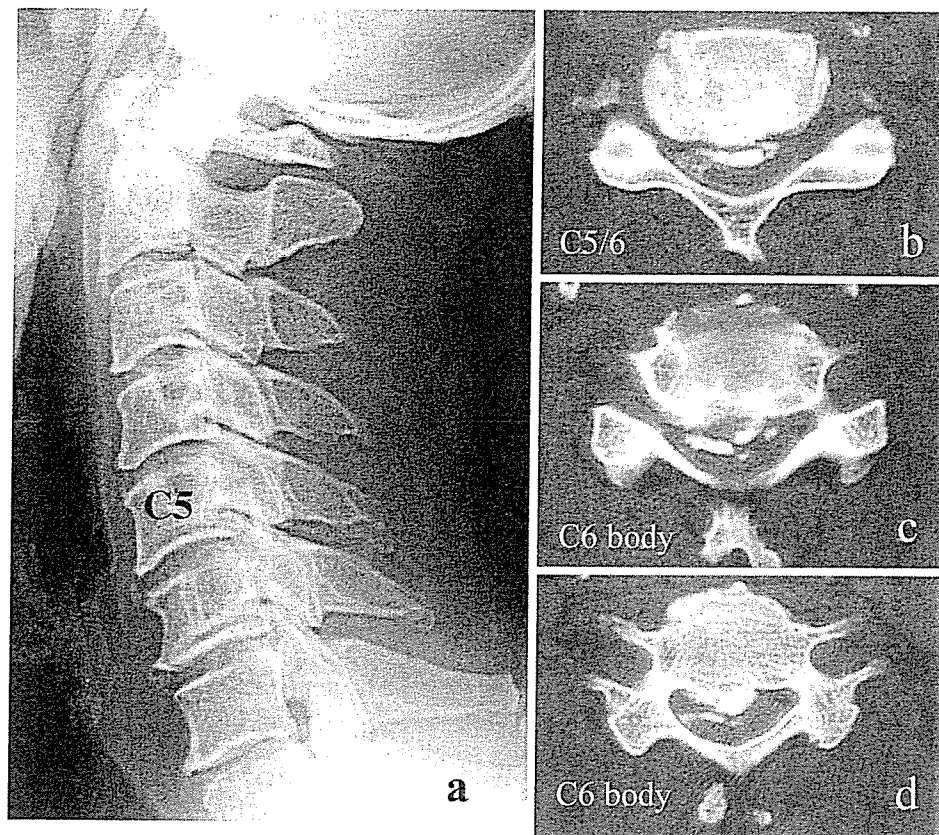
Segmental-type OPLL in a 62-year-old man. a Radiograph shows segmental OPLL at the C4, C5, and C6 levels. b CT-myelogram shows thin laminated ossification behind the C5-C6 disc. It is also seen at the upper part (c) and lower
